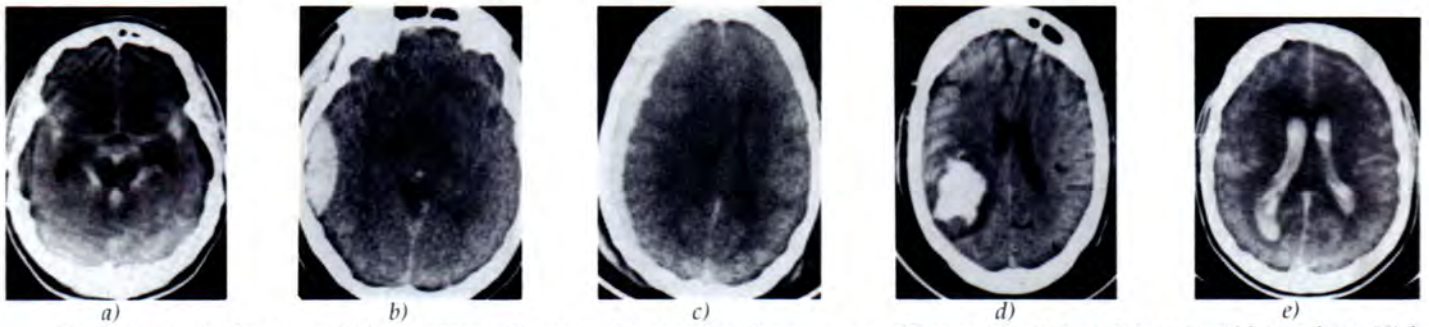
Diagnosis of intracranial hemorrhage or hematoma based on location as seen on CT scan of head. 2. a) Subarachnoid hemorrhage. High signal attenuation due to blood collection evident in basal cisterns encircling the brain stem and other CSF spaces including the Sylvian fissure, interhemispheric fissures and sulci. 2b) Epidural hematoma. Blood collection outside the dura evident over right parietal region with typical biconvex appearance as dura is peeled from its adhesion to the inner table of the skull. 2c) Subdural hematoma. Extensive extra-axial (peripheral) blood over right hemisphere with flat or concave inner margin. 1-2 cm midline shift away from the lesion is seen. 2 d) Intraparenchyma hemorrhage (hemorrhagic contusion). Obvious well demarcated high density lesion in right parietal region with surrounding low-density edema. 2.e) Intraventricular hemorrhage. High density material within the ventricles indicates the presence of blood.
